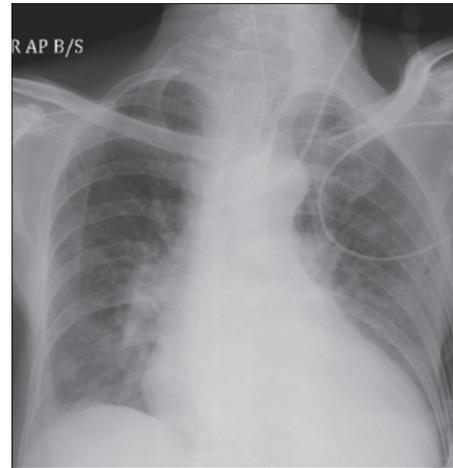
X-ray post central line insertion
